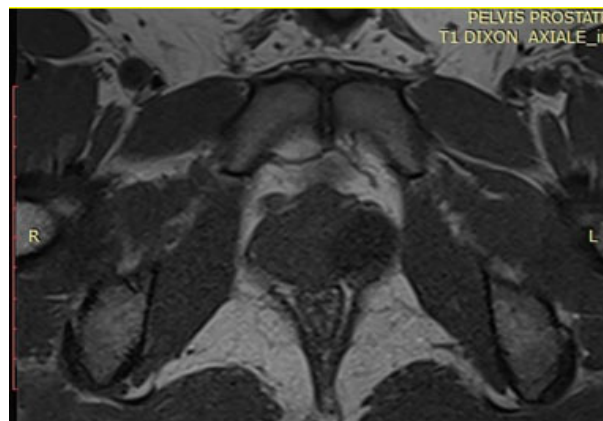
T1 MRI cross-section showing implantation in the prostate urethra.
